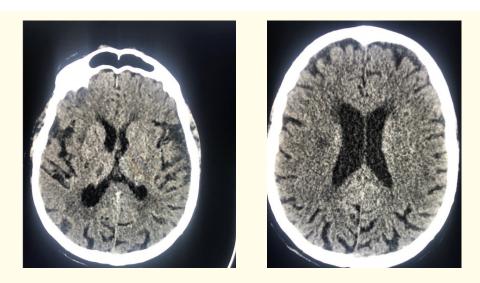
Images of computed tomography of brain.
